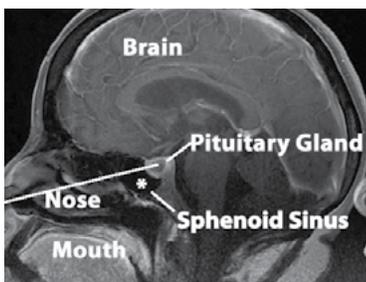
Sagittal T1 MRI post contrast of the brain. The surgical trajectory is indicated by the oblique line. The sphenoid sinus is indicated by the *.
